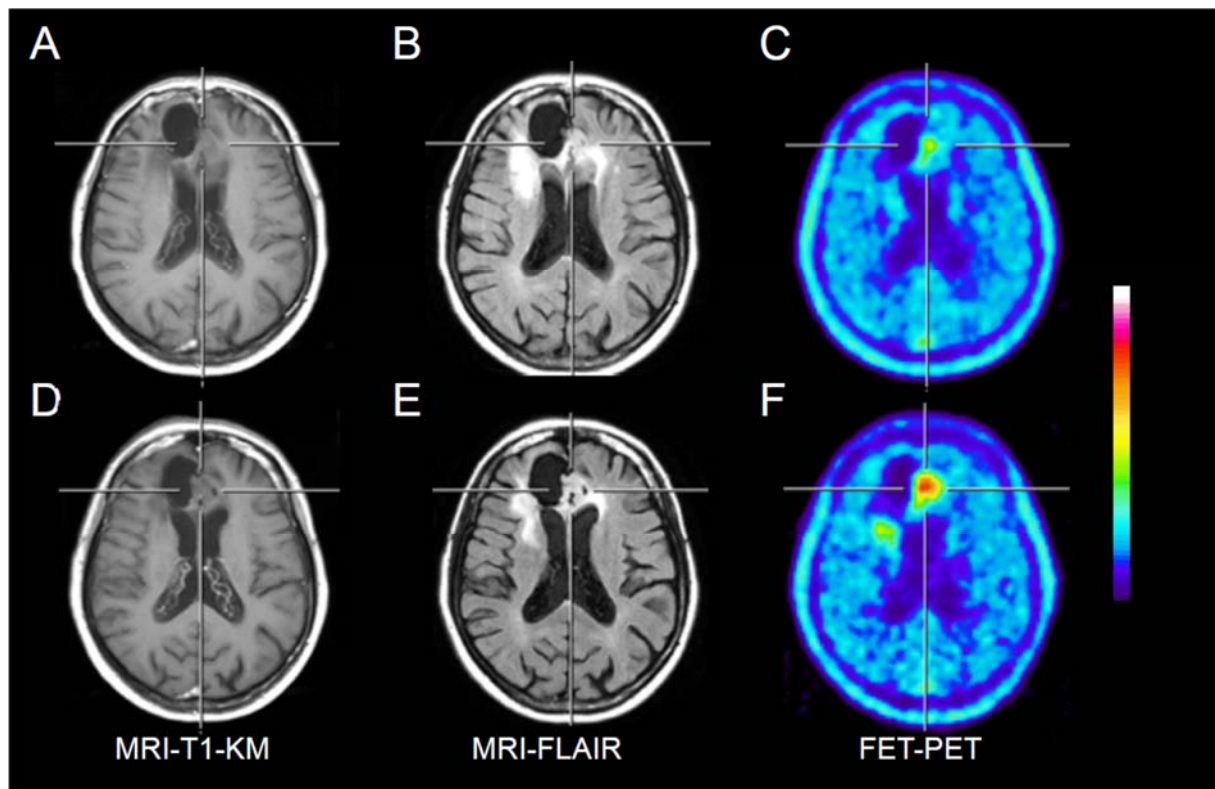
Patient with an oligodendroglioma WHO grade II after surgery and repeated chemotherapy with temozolomide (upper row). One year later (lower row) contrast enhanced T1-weighted MRI (D) shows no contrast enhancement and the FLAIR image (E) minor changes which are difficult to differentiate from treatment-related changes. FET-PET (F) findings are consistent with recurrent tumor. Institute of Neuroscience and Medicine, Forschungszentrum Jülich, Germany.
